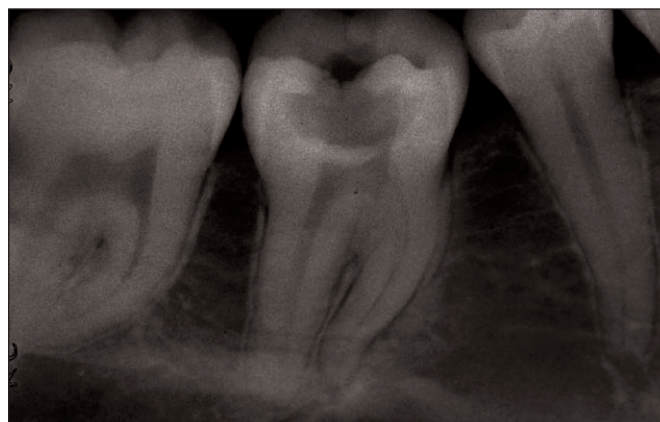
Great dentin destruction and no periapical alteration at the periapical radiograph.
